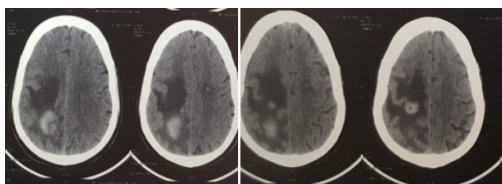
CT brain(plain) showing haemorrhagic cerebral metastases in a patient with denovo detected Renal Cell Carcinoma
